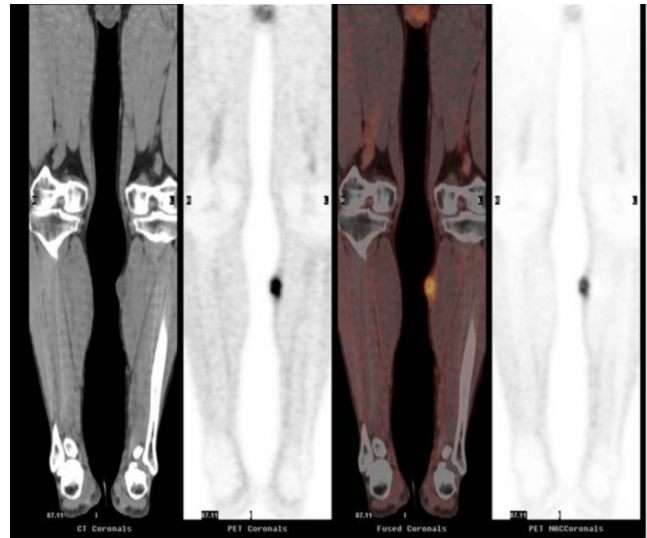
Coregistration of coronal CT Images with ¹⁸FDG PET image. Intense pathological FDG uptake (SUV 9.1) is present on initial ¹⁸FDG PET examination coregistering with superficial soft-tissue mass, consistent with biologic tumor activity.
